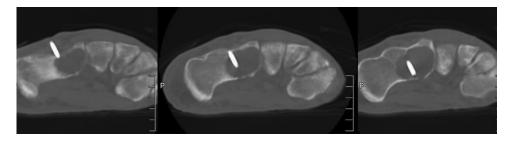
CT-guided core needle biopsy of the lesion
